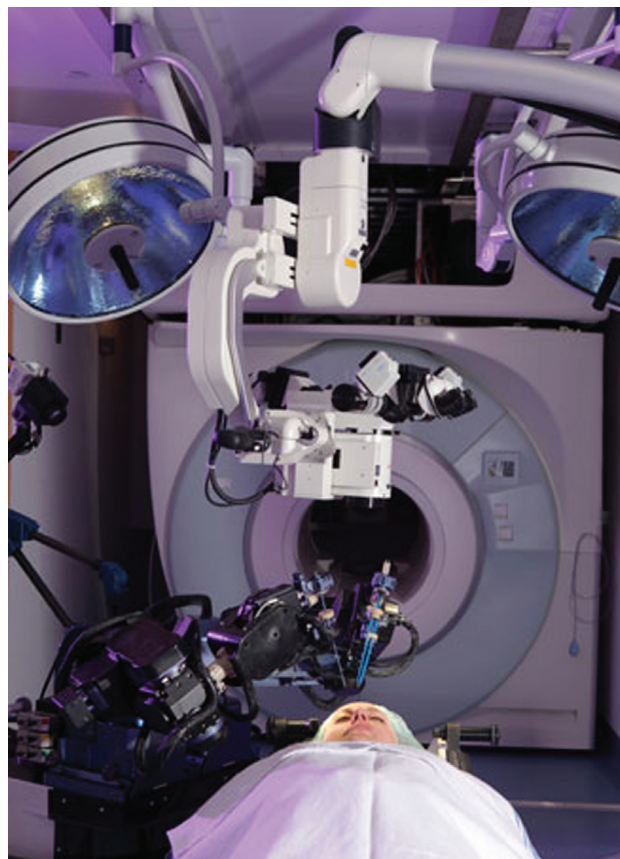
NeuroArm (University of Calgary, Alberta, Canada) is a magnetic resonance imaging-computable master/slave system capable of several surgical tasks. Image courtesy of University of Calgary.
